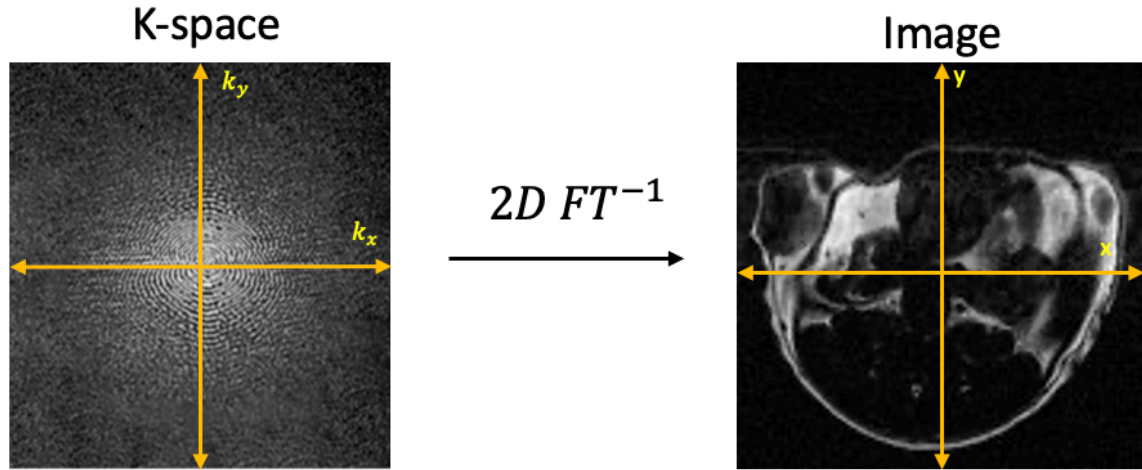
K-space and its Fourier transform: an MR image. The lines in the k-space represent data points collected in each phase encoding step (k_y).*
